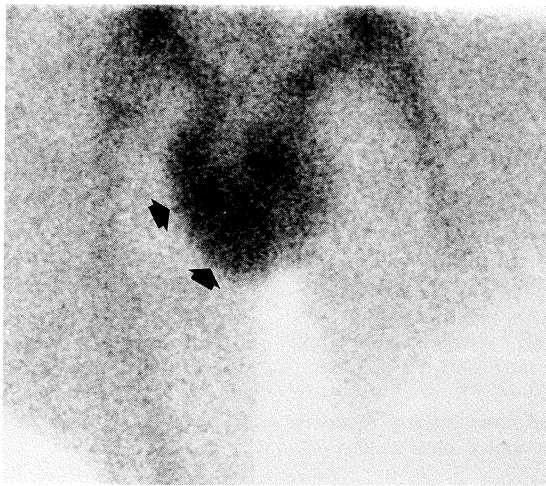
Epididymo-orchitis. Testicular scintigraphy, static image, shows diffuse increased uptake in the right testis (arrows).
